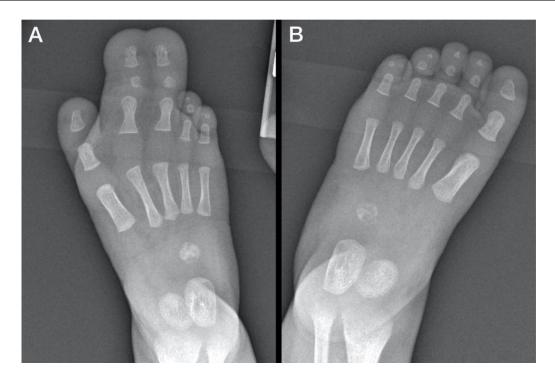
(A) Plain film radiograph of the right foot demonstrates diffuse enlargement and complete failure of segmentation of the right second and third toes with enlargement of the associated phalanges. (B) In comparison, plain film radiograph of the left foot is radiographically normal.
